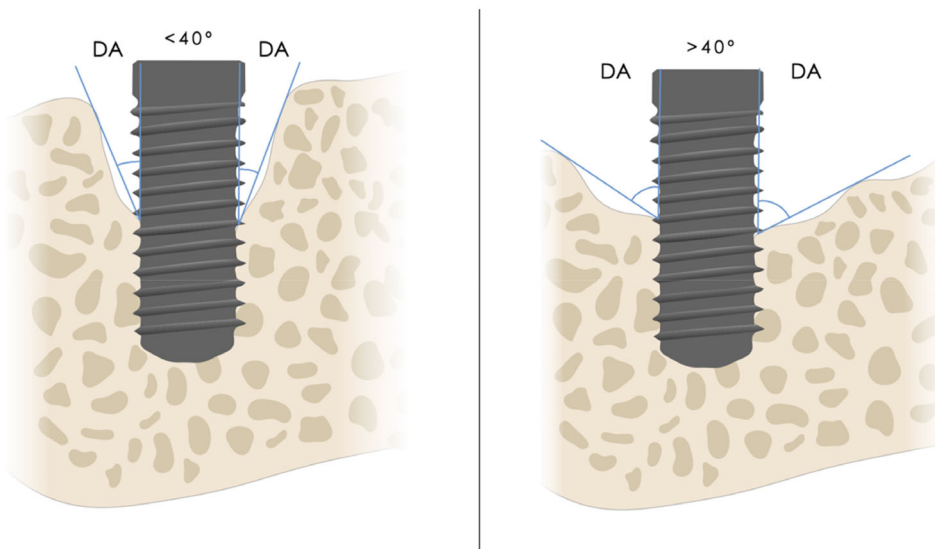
Defect angle (DA) demonstrated predicting radiographic bone gain. Narrow DA ($<40^\circ$) was more prone to achieve greater bone level gain.
